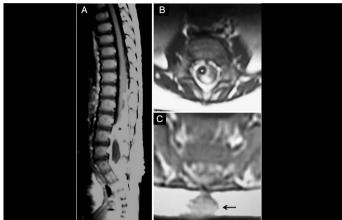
T1 magnetic resonance images with gadolinium of an eight-month-old girl with sacral DSCI at level S2 (Case 1). The DS tract is recognizable in the subcutaneous cellular tissue (arrows) with arachnoiditis and an intradural lumbar abscess (asterisk). A. Sagittal T1 MRI with gadolinium. B. Axial T1 MRI with gadolinium at lumbosacral-lumbar level 5. C. Axial T1 MRI with gadolinium at level S2.
